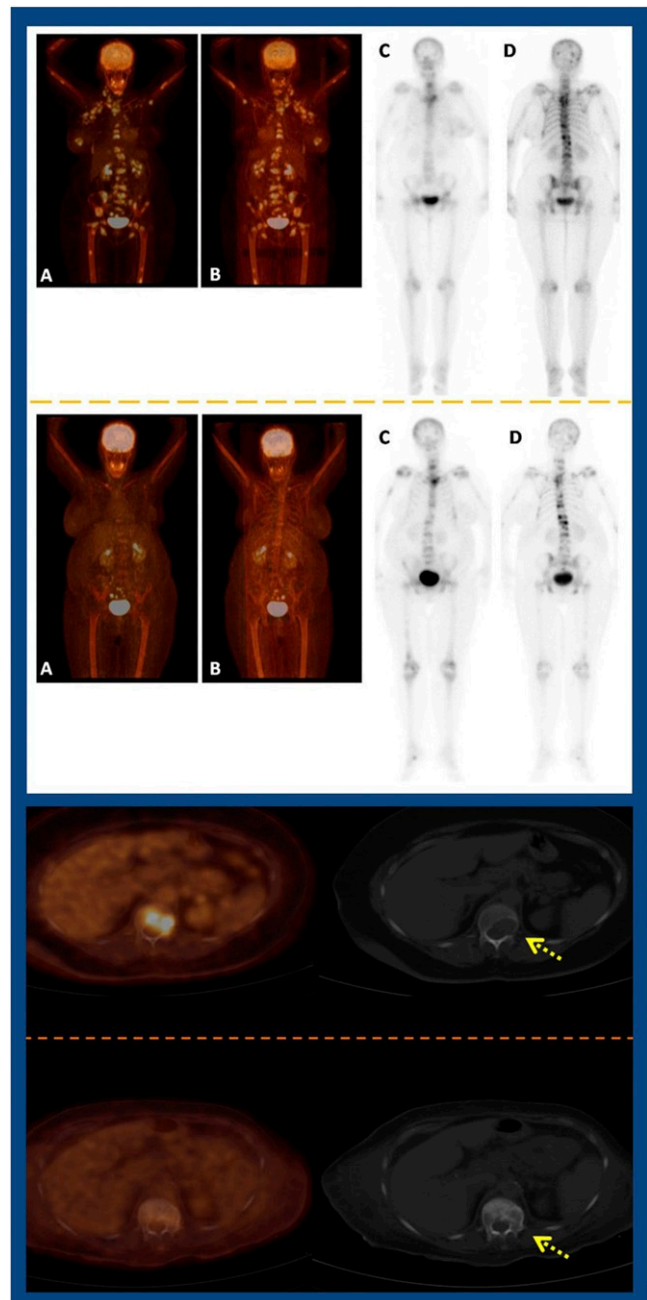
^{18}F -FDG PET/CT and ^{99m}Tc -MDP bone scintigraphy in estimation of metastatic osseous burden in breast cancer patients. A semiquantitative metastatic osseous score based on PET was more closely correlated with changes in tumor and bone markers than bone scan score. Top, left block, top and bottom: ^{18}F -FDG PET/CT imaging in 2 patients before and after treatment. Middle block: Comparative ^{99m}Tc -MDP bone scintigraphy before and after treatment in the same patients. PET scores decreased but the bone scan scores remained the same. Bottom block: Example of an ^{18}F -FDG-avid lytic lesion that became non-FDG avid after treatment and was sclerotic on follow-up.
